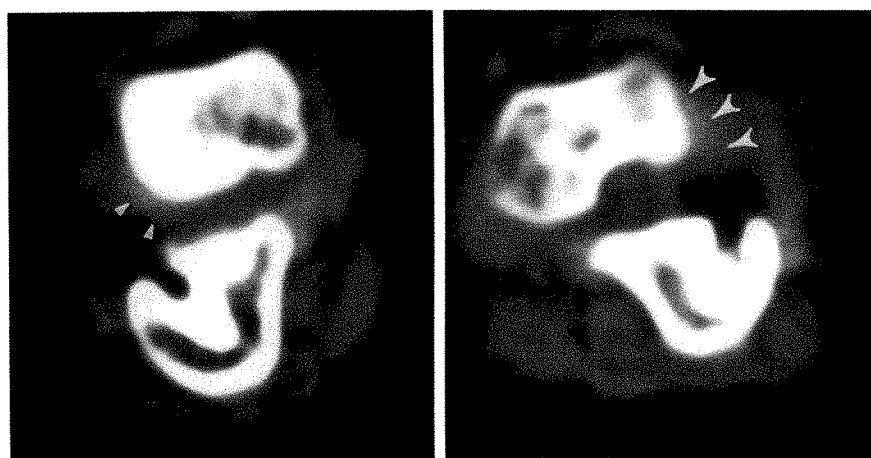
Coronal CT scans of bilateral STA-Peg arthroplasties in 4-year-old boy.
